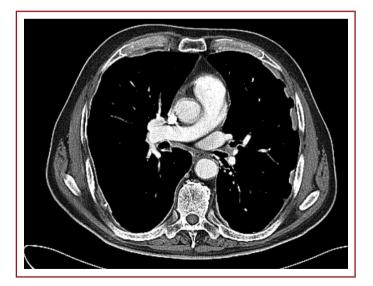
Mediastinal window of an axial high-resolution computed tomography image (W: 350, C: 50) shows asbestos-related pleural plaques on the left lung in a 65-year-old man who has worked for 25 years in a clutch plate manufacturing factory.
